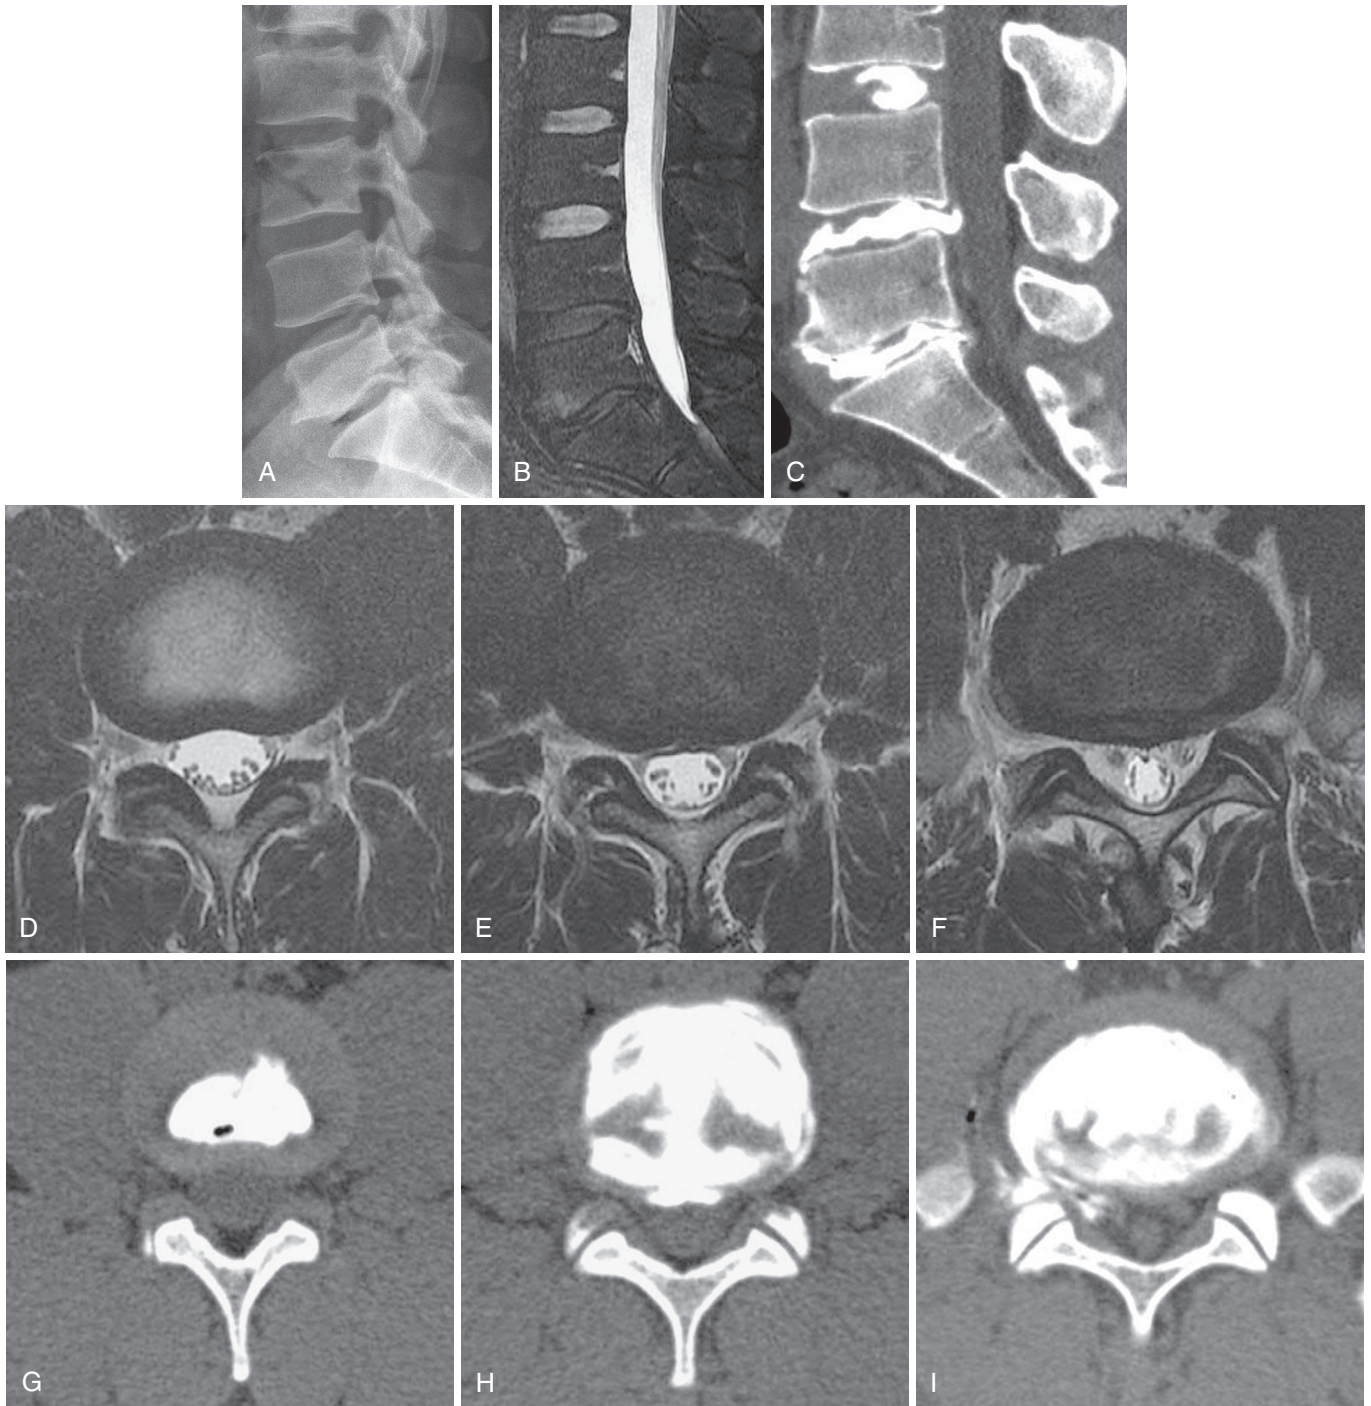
Disk height and nuclear T2 signal loss. Lateral radiograph (A) of a 50-year-old male with intractable axial pain. Note loss of height of lumbosacral disk, which contains gas. There is slight retrolisthesis of L4 on L5 and L5 on S1. Sagittal fat-saturated T2-weighted MRI (B) shows loss of T2 signal in the L4-5 and L5-S1 disks; normal upper lumbar disks. Axial T2-weighted images at L3-4 (C), L4-5 (D), and L5-S1 (E) demonstrate normal L3-4 disk, loss of T2 signal in L4-5 with a small central herniation, and a broad bulge at L5-S1. Sagittal CT diskogram (F) and axial images at L3-4 (G), L4-5 (H), and L5-S1 (I) shows normal L3-4 disk, Grade IV annular disruption at L4-5 and L5-S1 with leak of contrast from the right posterolateral annulus at L5-S1. Patient had concordant axial pain at L4-5 and L5-S1 with a normal control disk at L3-4. (From Maus TP, April CN. Lumbar discogenic pain, provocation diskography, and imaging correlates. *Radiol Clin North Am.* 2012;50:681-704.)
